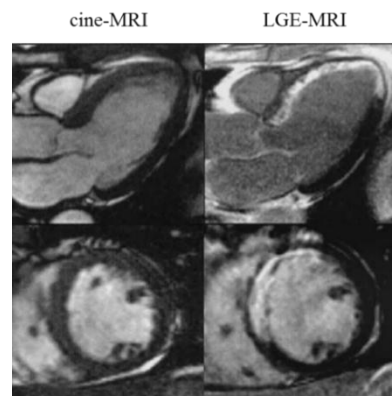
Representative long-axis (top) and short-axis (bottom) T_1 -weighted gradient-echo MRI (left) and LGE-MRI (right). Adapted from [Beek 2003].
